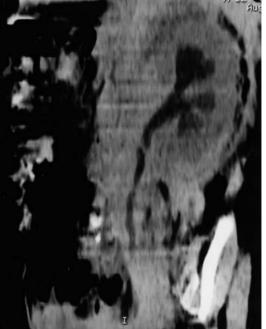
Retroperitoneal malignant fibrosis (leukemic infiltration) determining bilateral ureterohydronephrosis visualized on a CT scan without contrast injection. a Transverse scan. b Oblique 2D reconstruction showing the ureteral entrapment
